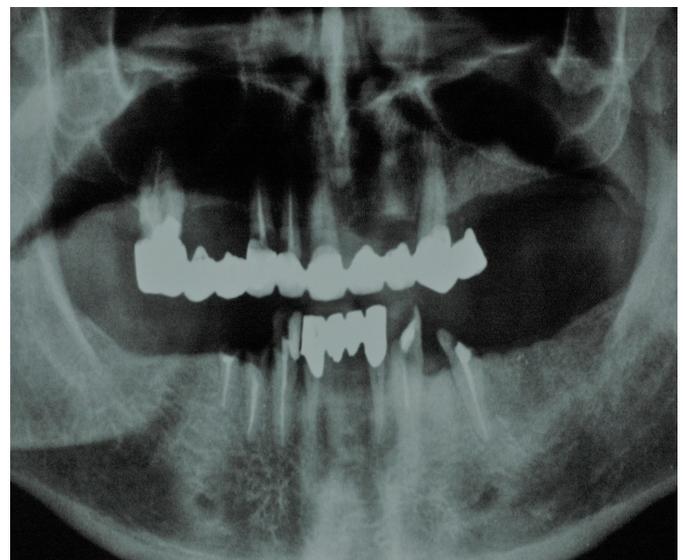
Radiographic image of the patient's pre-treatment status.
